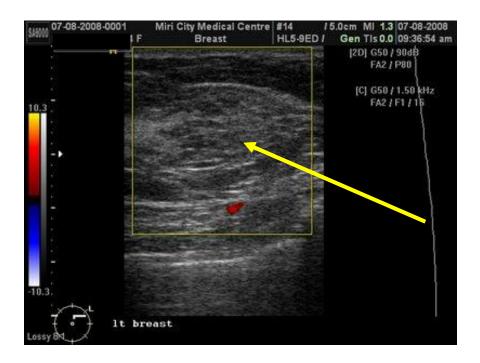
[13]: Ultrasound showed a 3cm solid mass in the upper outer quadrant of the left breast (yellow arrow). As she is over 40 years of age and the mass is more than 2cm, a biopsy is recommended.
